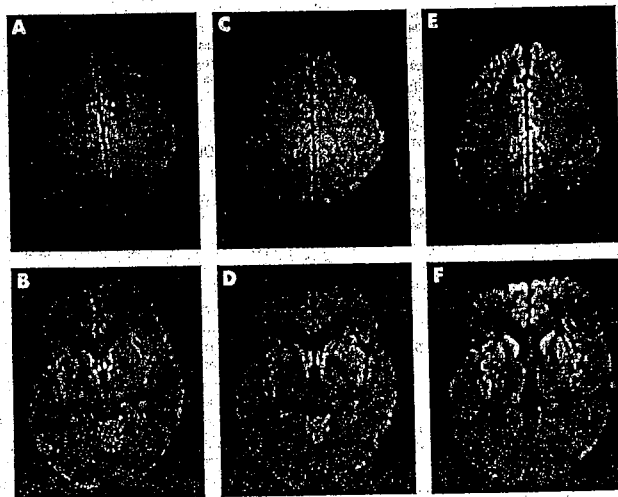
Magnetic resonance imaging (MRI) 1 month (panels A and B), 2 months (C, D) and 3 months (E, F) after onset. Diffusion weighted imaging (DWI) 1 month after onset revealed bilateral frontomesial hyperintensities (A), and moderate DWI signal increases in the medial portion of both caudate heads (B). Two months after onset, the bifrontal hyperintensities showed slight enlargement (C), and DWI signals were elevated in both caudate heads, the adjacent putamina and insular cortices (D). On follow-up MRI 1 month later, there was increased DWI signal in the frontomesial and frontopolar cortex (E,F) and marked DWI hyperintensity in both caudate heads, both putamina with accentuation in their rostral parts, and both insular ribbons (F). AOC maps and FLAIR images were inconspicuous (data not shown).
